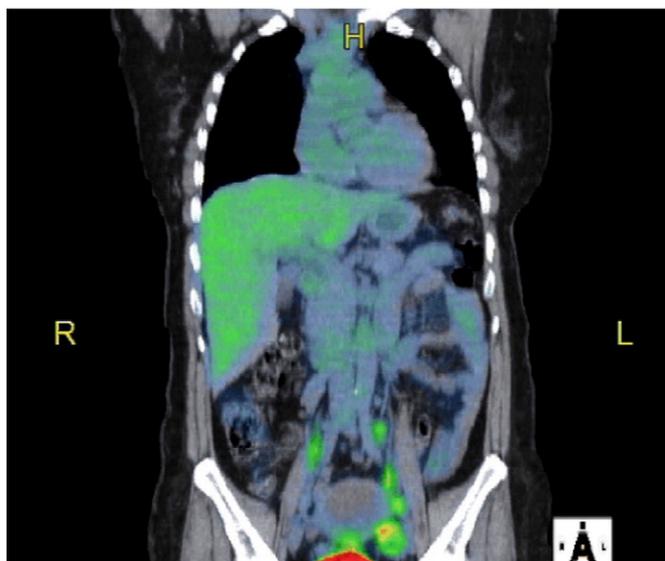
Presurgical PET scan fused with computed tomogram reveals bilateral pelvic and common iliac adenopathy.
